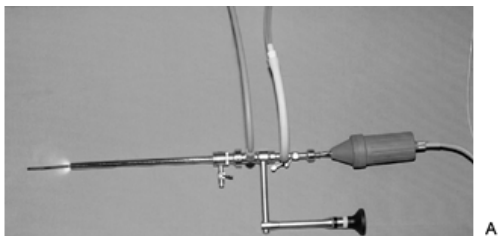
A: Rigid nephroscope with offset lens allows passage of a rigid Sonotrode. B: The nephroscope and ultrasound wand are placed through the working sheath. The ultrasound wand is abutted against the stone and ultrasonic energy applied, with simultaneous suction of fragments through the hollow Sonotrode.
